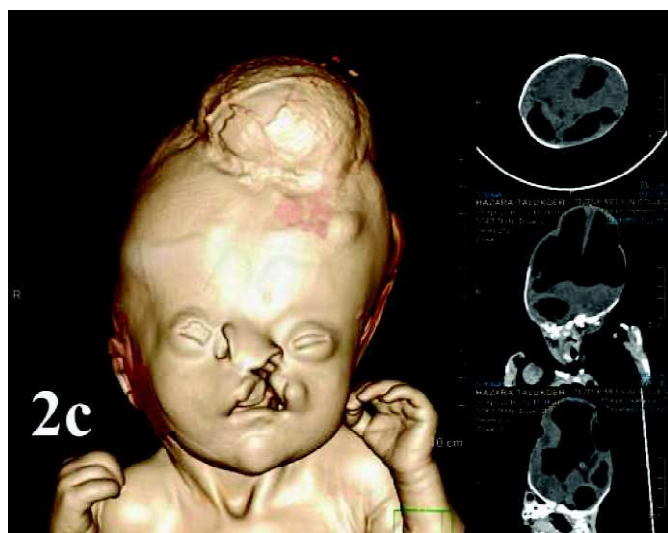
CT scan with 3D imaging showing cranial, facial and orbital deformities
